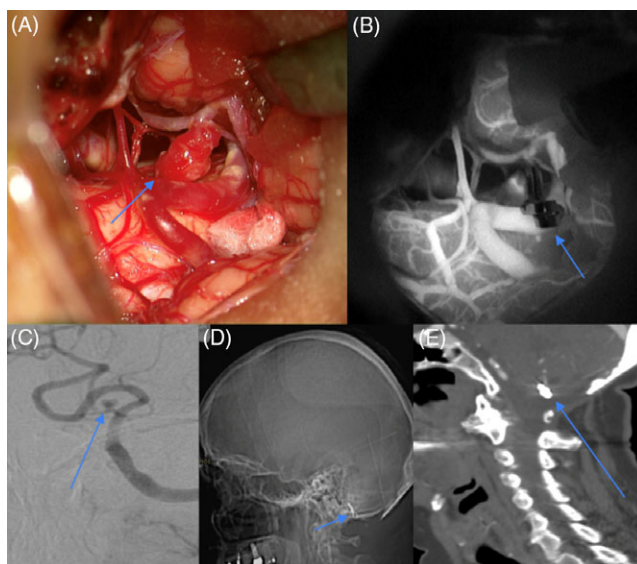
(A) Intraoperative photography showing the aneurysm and parent artery (arrow); (B) Indocyanine green intraoperative angiography showing clipped aneurysm with no flow in the sac (arrow); (C) pre-operative cerebral angiogram, left vertebral injection A/P projection with aneurysm (arrow); (D) & (E) Post-operative CT scout and sagittal CT showing clip in situ (arrows).
